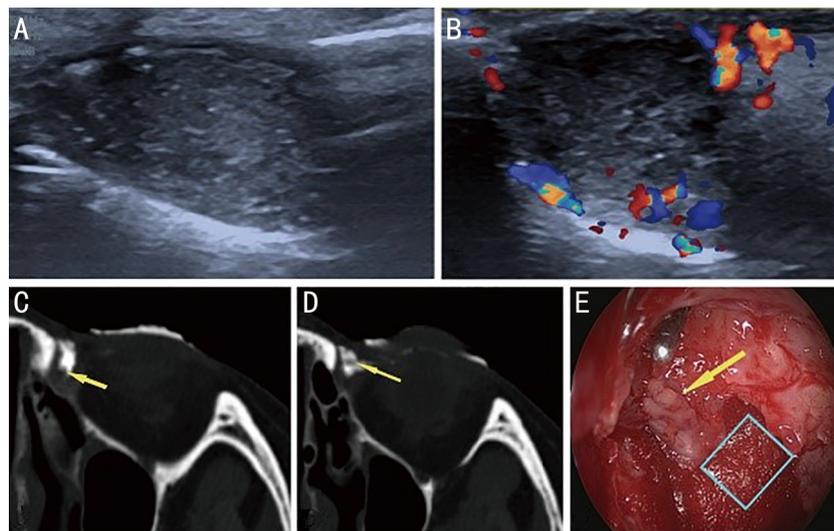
Imaging features of inflammatory granuloma complicated with concretion in CDU and CT-DCG A: An irregular shape mass with an unclear edge and uneven internal echoes inside, with the bottom adhering to the lacrimal sac; B: CDU showed speckled blood flow near the sac wall; C: CT-DCG showed extensive irregular soft-tissue filling defect with an uneven margin attached to the lacrimal sac wall (yellow arrow); D: CT-DCG showed a filling defect of soft tissue not adjacent to the lacrimal sac wall (yellow arrow); E: Granulomatous hyperplasia can be observed on the wall of the lacrimal sac during surgery (yellow arrow). The blue rectangular area represents the intraoperatively resected mucosa for pathological examination. CDU: Color Doppler ultrasound; CT-DCG: Computed tomography dacryocystography; CT: Computed tomography.
